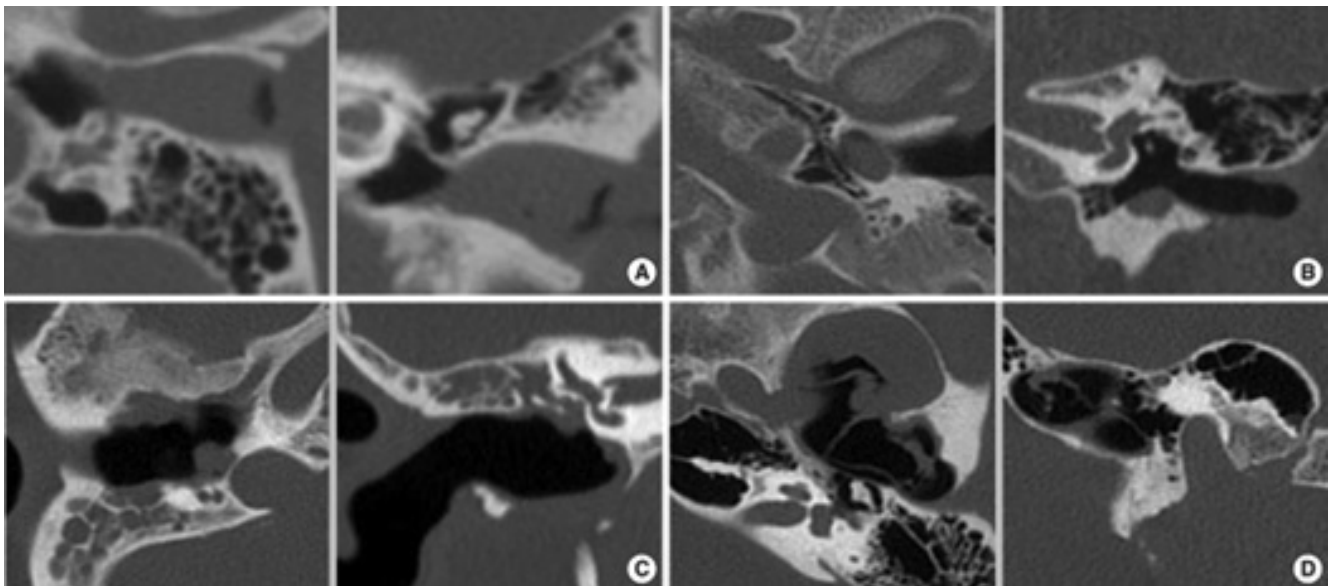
Radiology of the stages of ACC: A = I; B = II; C = III; D = VI. Reproduced from Shin et al. Classification of external auditory canal cholesteatoma by computed tomography. *Clin Otorhinolaryngol* 2010; 3: 24–6.³²
